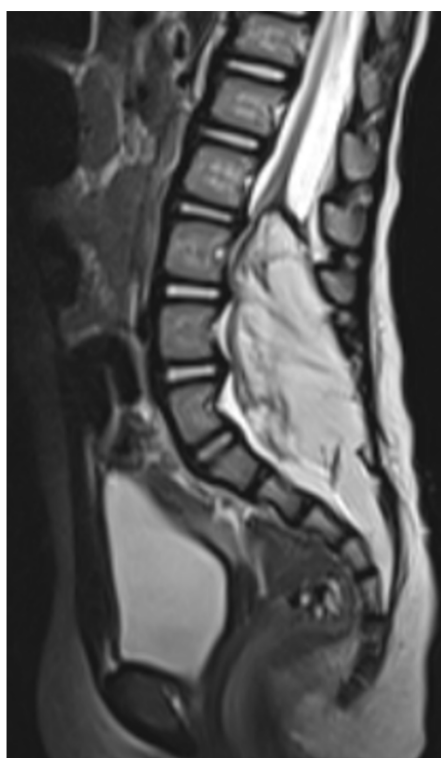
A sagittal MRI T1 shows a spinal lipoma.
